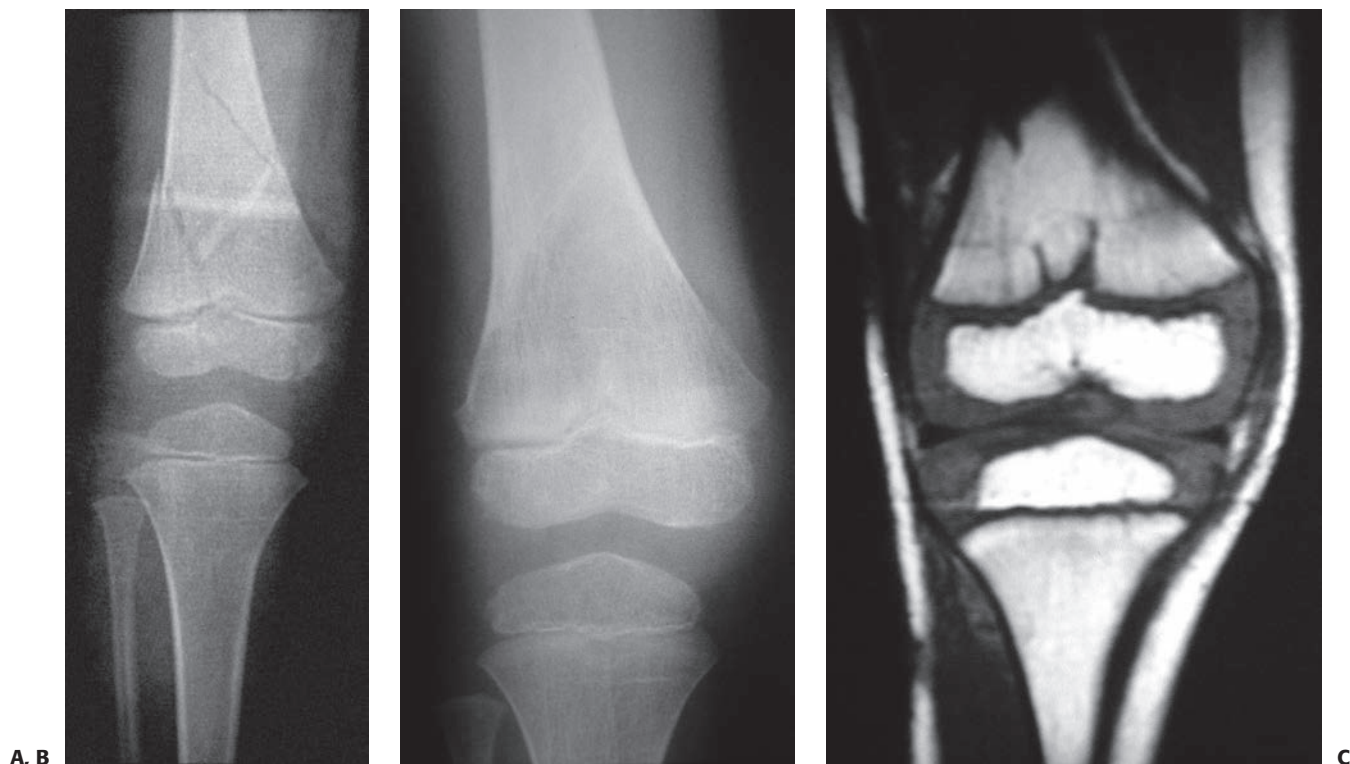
Five-year-old boy hit by car with fracture of the distal femur. A: AP radiograph of minimally displaced Salter–Harris type IV fracture of the distal femur. B: AP radiograph of healed fracture. From this view, it is difficult to determine if injury to the physis has occurred, though a central growth arrest was suspected. C: MRI shows a central growth plate injury probably did occur, although this did not result in formation of a bony bar or growth arrest. (Courtesy of Robert Kay, MD, Los Angeles, CA.)
